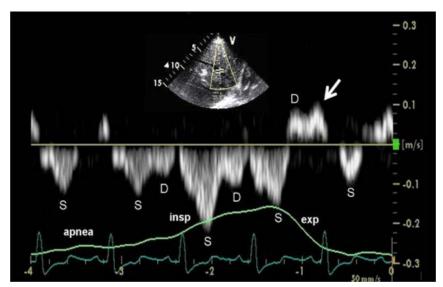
PW Doppler recording of hepatic venous flow velocity in a patient with cardiac tamponade. Flow below the zero baseline is toward the heart and above the baseline is reverse flow. Compared with normal forward flow, velocities in tamponade are markedly reduced, reflecting reduced cardiac filling. During apnea, forward flow is seen only during ventricular systole (S). With inspiration (insp), systolic flow predominates, but diastolic flow (D) also appears. On the first beat of expiration (exp), there is a diastolic flow reversal (arrow). This reversal is at the same time tricuspid inflow is lowest (Figure 34). SVC flow velocity (not shown) continues to show some diastolic forward flow on this first beat of expiration.
